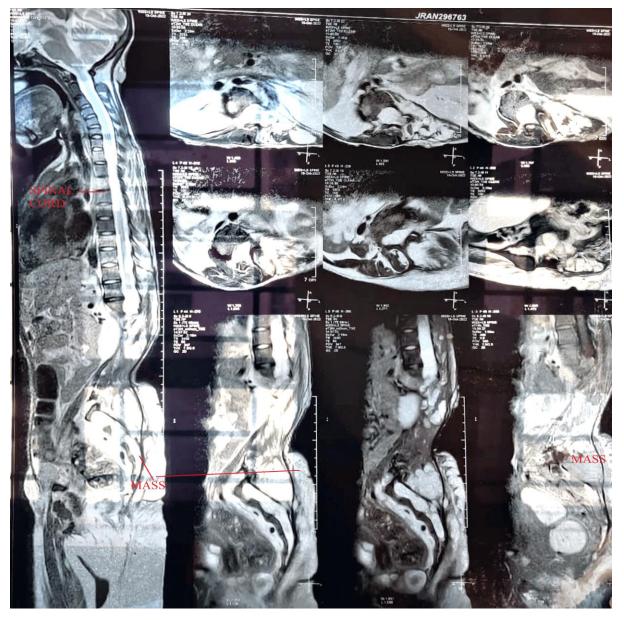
MRI imagine of the lesion showing it's relation with the spinal cord
